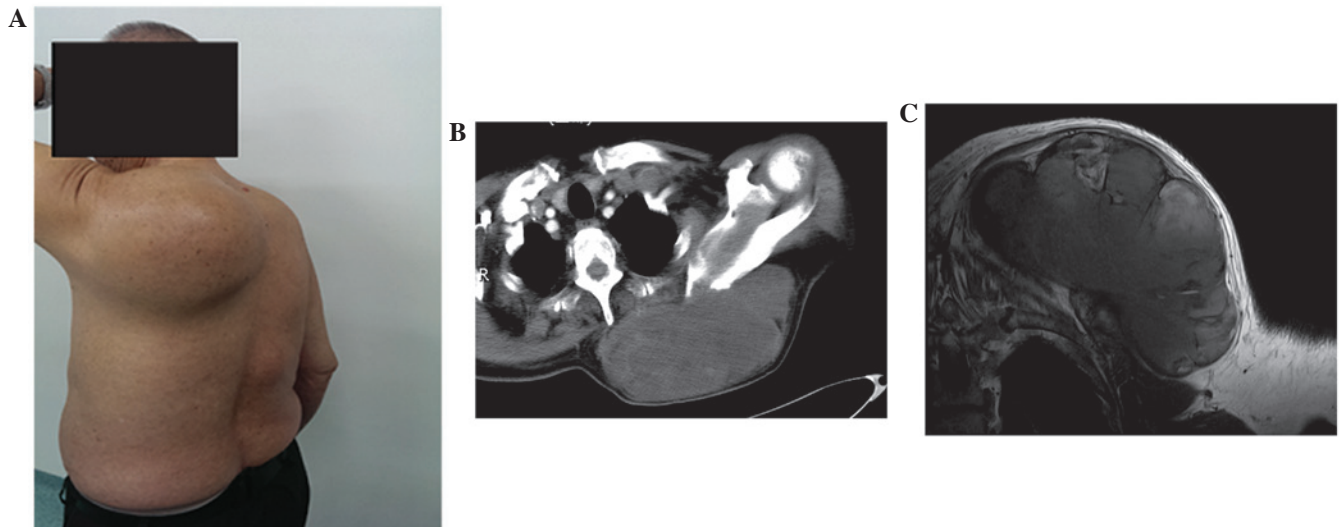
Preoperative observations. (A) The primary clinical feature was a painless giant mass located on the left humeral back. (B) Computed tomography scanning revealed a giant mass with homogeneous density and no bone destruction, ~17x16x10 cm in size. (C) Magnetic resonance imaging scanning revealed that the mass exhibited multiple linear low signal intensity strands on the T1 weighted image, with well-defined margins.
